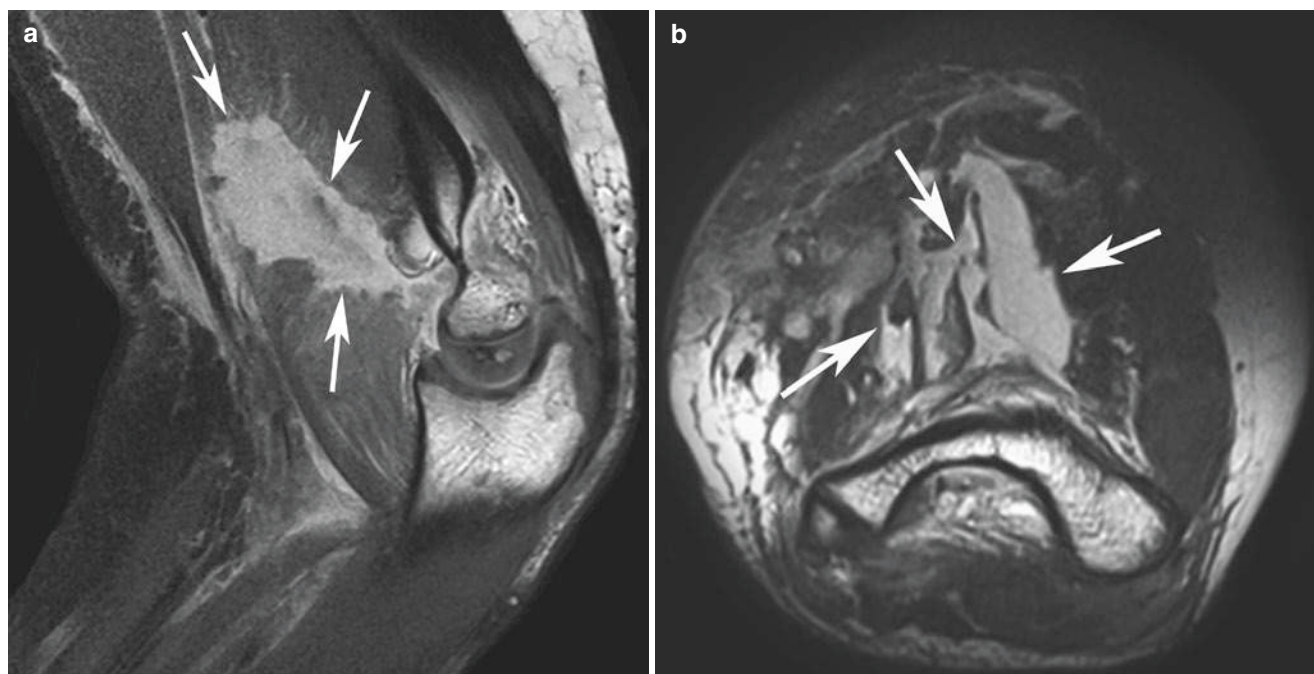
(a–d) Brachialis muscle tear and brachial artery occlusion in 13-year-old boy after elbow dislocation. Sagittal (a) and axial (b) PD images show rupture of nearly the entire distal brachialis muscle (*arrows*). (c) Coronal 2D reconstruction from computed tomographic
